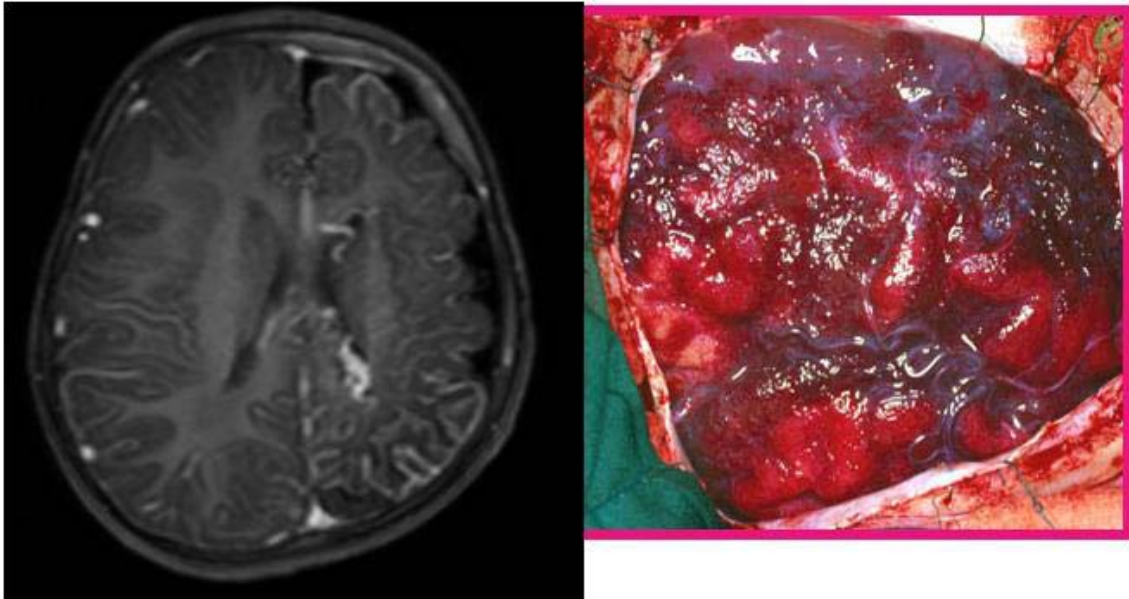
T2W Axial Flair MRI Image (A) of a patient with right hemimegalencephaly showing an enlarged right hemisphere with thickened cortical mantle, distorted ventricular anatomy and widened gyri (B) Intraoperative photograph
